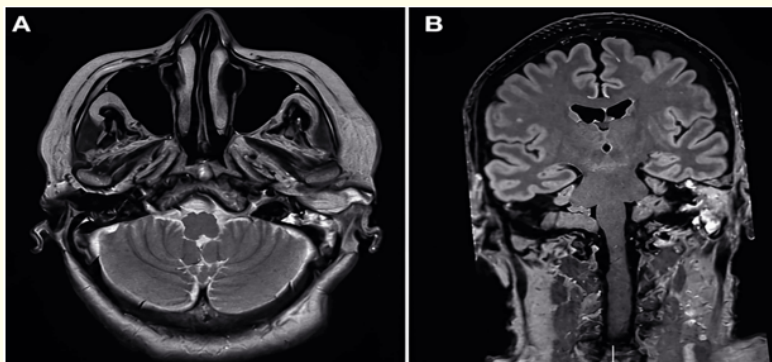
Axial and coronal MRI showing a hyperintense lesion with contrast enhancement involving the tympanojugular region.
